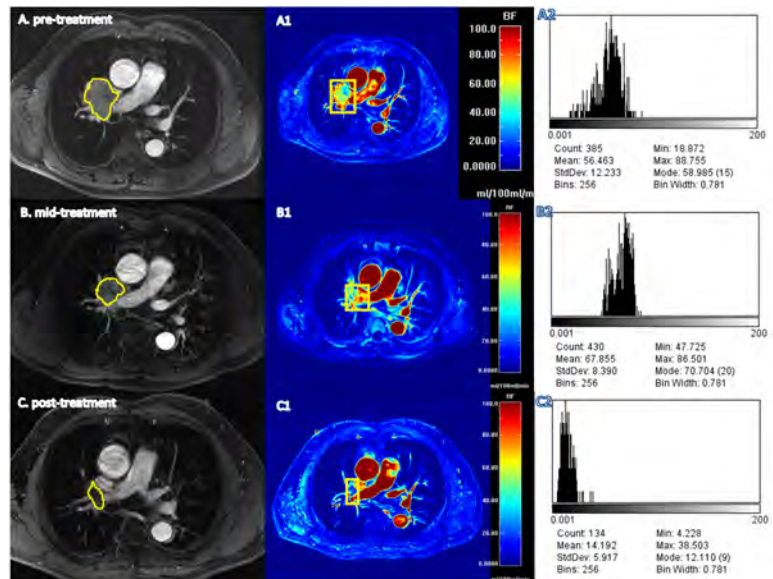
A 61-year-old man with non-small cell lung cancer, who had a good response of concurrent chemoradiotherapy was shown. A. before therapy (pre-treatment), B. 2 weeks after therapy (mid-treatment) and C. at the end of therapy (post-treatment). Axial color-coded BF maps of DCE-MRI at pre-treatment (A1), mid-treatment (B1), and post-treatment (C1). Histogram was shown on A2, B2 and C2, respectively.
